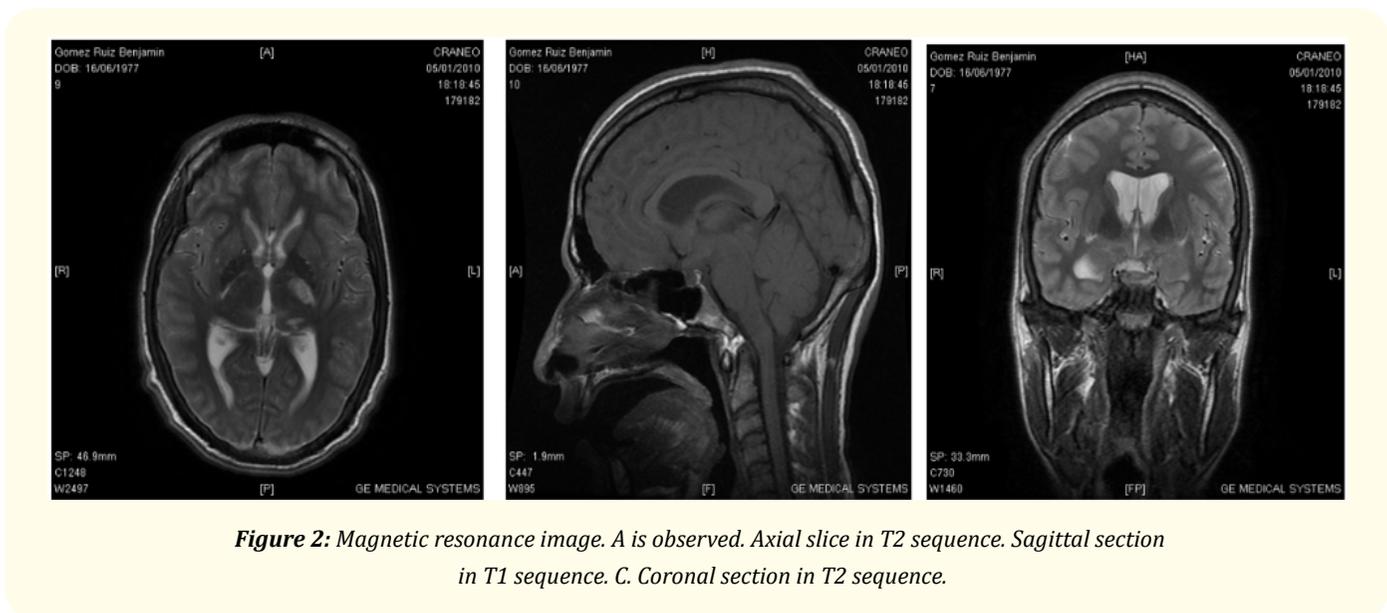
Magnetic resonance image. A is observed. Axial slice in T2 sequence. Sagittal section in T1 sequence. C. Coronal section in T2 sequence.
